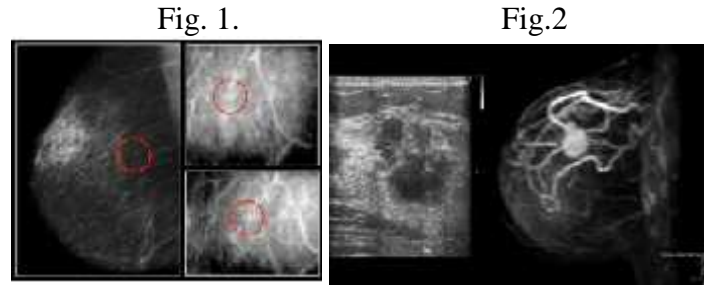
Example of early, in-situ breast cancer detected by screening mammography in a 52-year old woman. Suspicion of cancer is raised by detecting an area with microcalcifications (indicated by red circles) in the breast; images in the right panels represent enlarged details of the same area in two different projections. Fig.2. Imaging results obtained in a 40-year old woman in the regular screening for mammography show a mass with irregular margins in the upper inner quadrant of the left breast (maximum diameter 25 mm; image not available because performed in another centre). The patient was then referred for further characterization. Left panel: US imaging confirms the inhomogeneous mass with irregular margins in the left breast. Right panel: MRI with gadolinium contrast shows that the mass has ductal-type contrast enhancement, suggesting breast cancer (confirmed by needle core biopsy as infiltrating ductal carcinoma).
